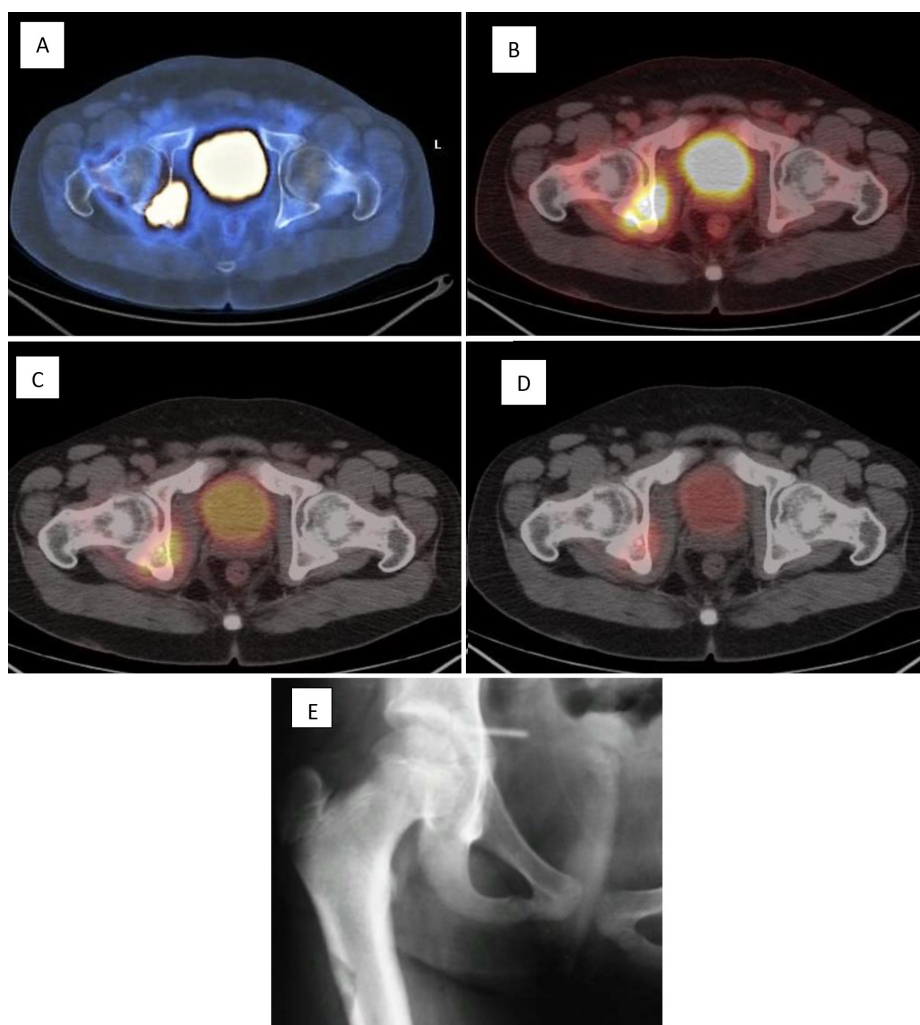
18F-FDG-PET-CT images of a 30yrs old male who presented with pain in the right hip for 2 months without any fixed deformity and was diagnosed as tuberculosis of right acetabulum showing (A) increased uptake before the start of ATT [SUVmax 5.8] and gradual decrease in uptake (B) at 2 months [SUVmax 4.2], (C) 6 months [SUVmax 2.1] and (D) after completion of ATT at 12 months with SUVmax of 0.9. Image (E) is the radiograph of the patient before the start of ATT showing sclerosis in the acetabulum
